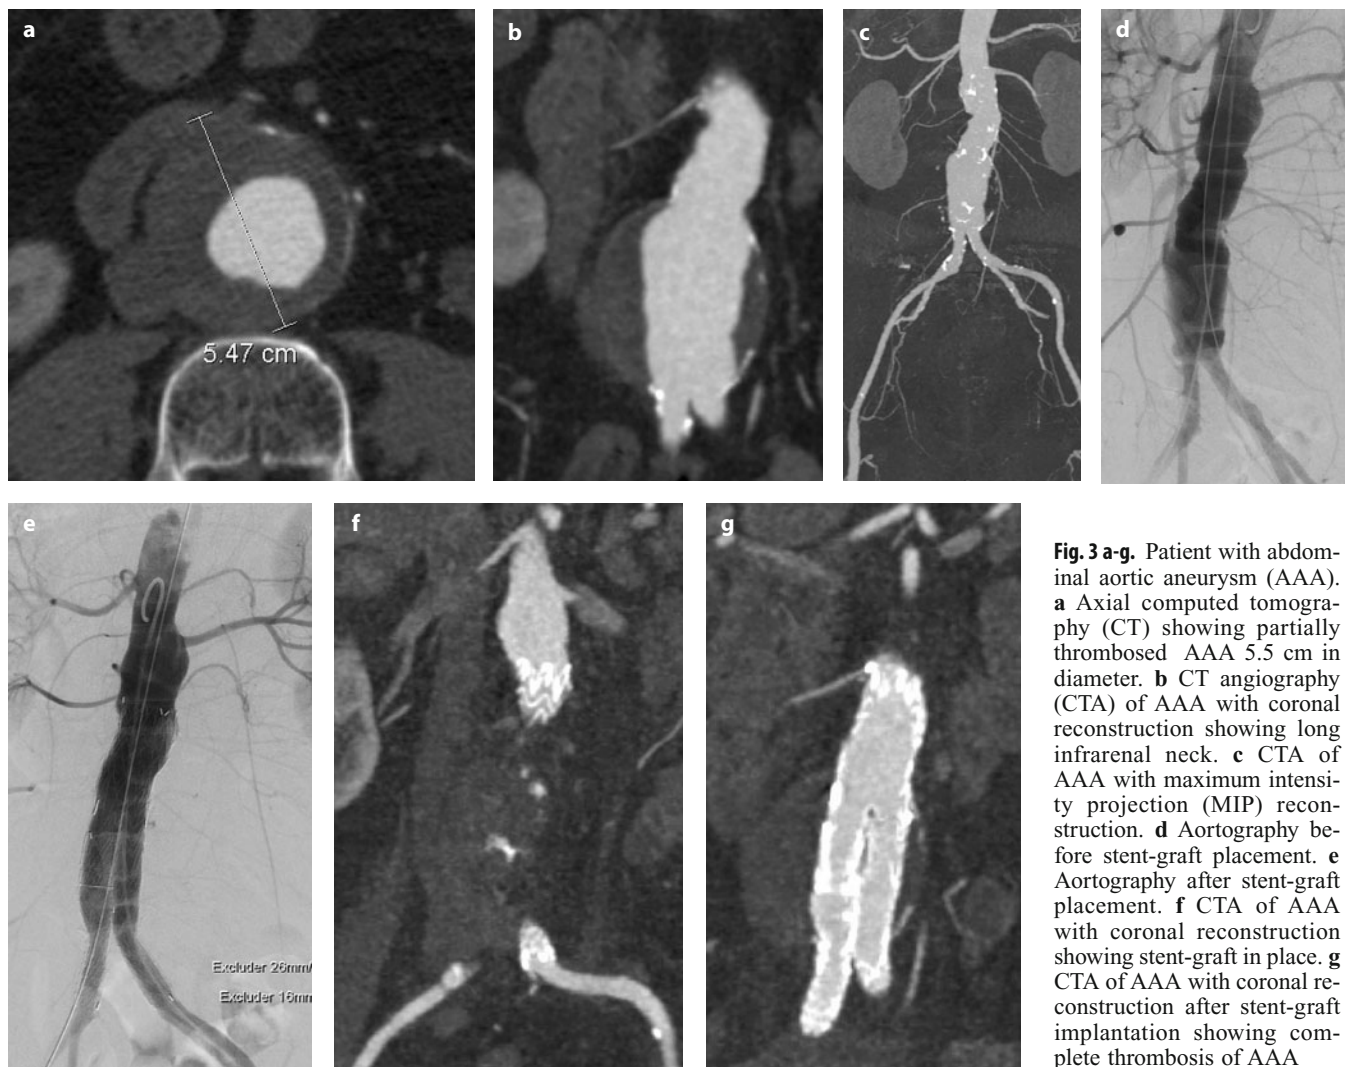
a-g. Patient with abdominal aortic aneurysm (AAA). a Axial computed tomography (CT) showing partially thrombosed AAA 5.5 cm in diameter. b CT angiography (CTA) of AAA with coronal reconstruction showing long infrarenal neck. c CTA of AAA with maximum intensity projection (MIP) reconstruction. d Aortography before stent-graft placement. e Aortography after stent-graft placement. f CTA of AAA with coronal reconstruction showing stent-graft in place. g CTA of AAA with coronal reconstruction after stent-graft implantation showing complete thrombosis of AAA
